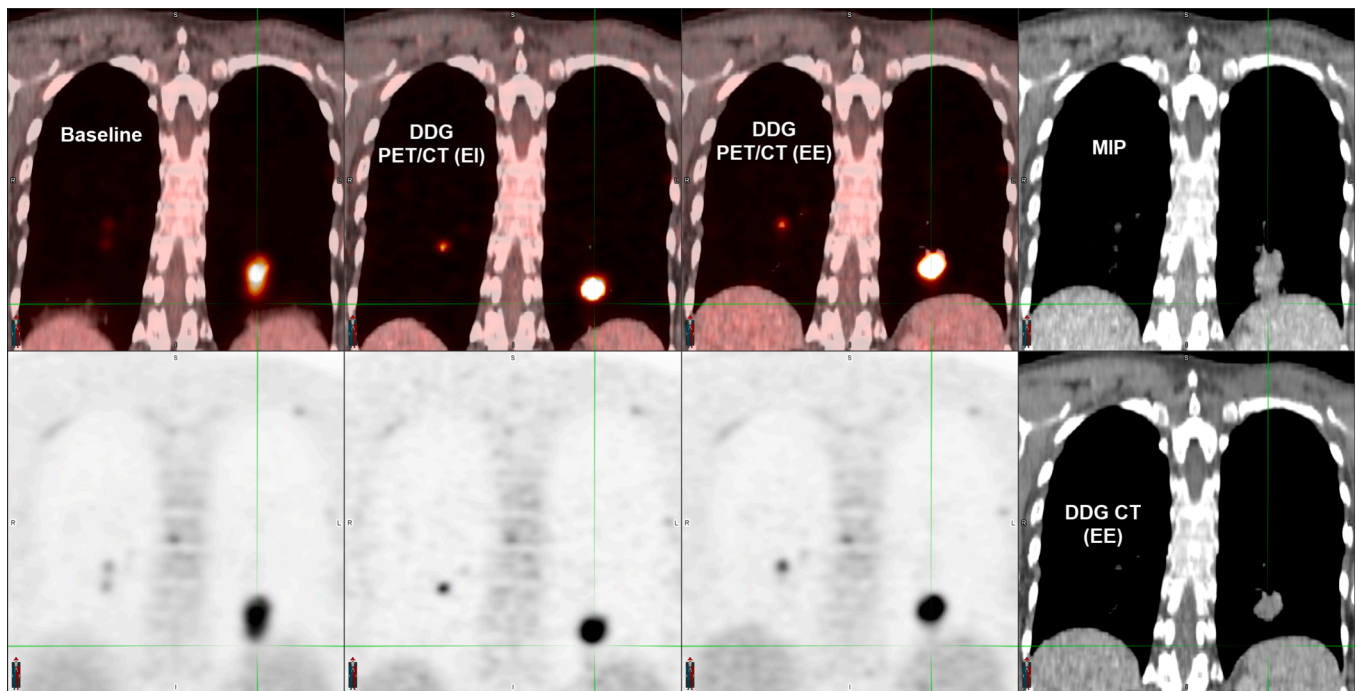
DDG PET/CT for RT of an ^{18}F -FDG study. The first three columns are the baseline WB PET/CT (the top is the fusion of PET and CT, and the bottom is PET only), DDG PET/CT at EI, and DDG PET/CT at EE. The MIP CT and DDG CT at EE are in the last column. The motion blur of the two lesions in PET was mitigated in both the EI and EE DDG PET/CT.
